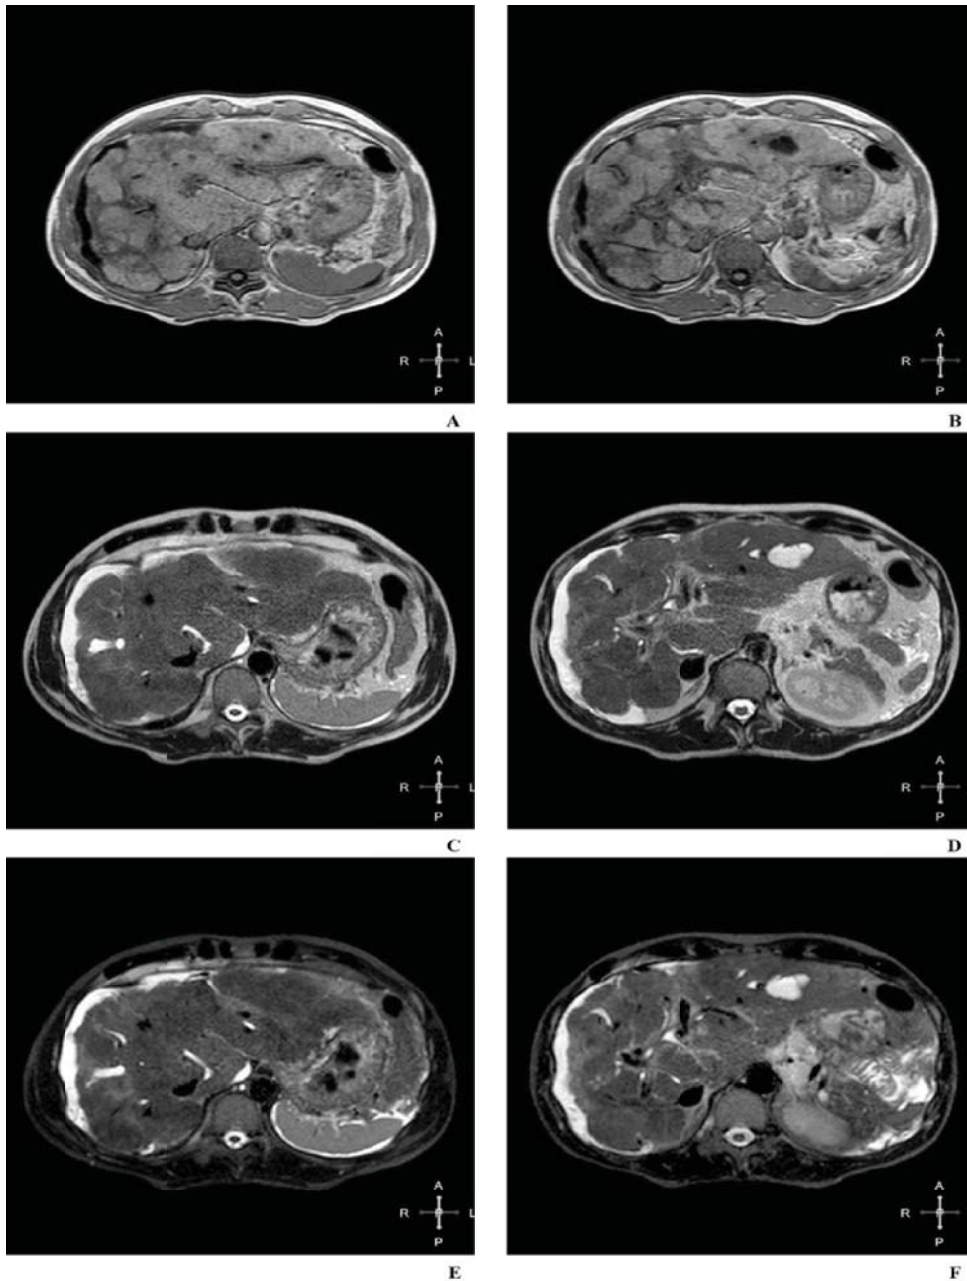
Dilatation of segmental bile ducts in hepatic right (A, C, E) and left lobe (B, D, F) in patient with liver cirrhosis and ascites. A, B – axial T1-weighted section; C, D – axial T2-weighted axial section; E, F – axial STIR section
